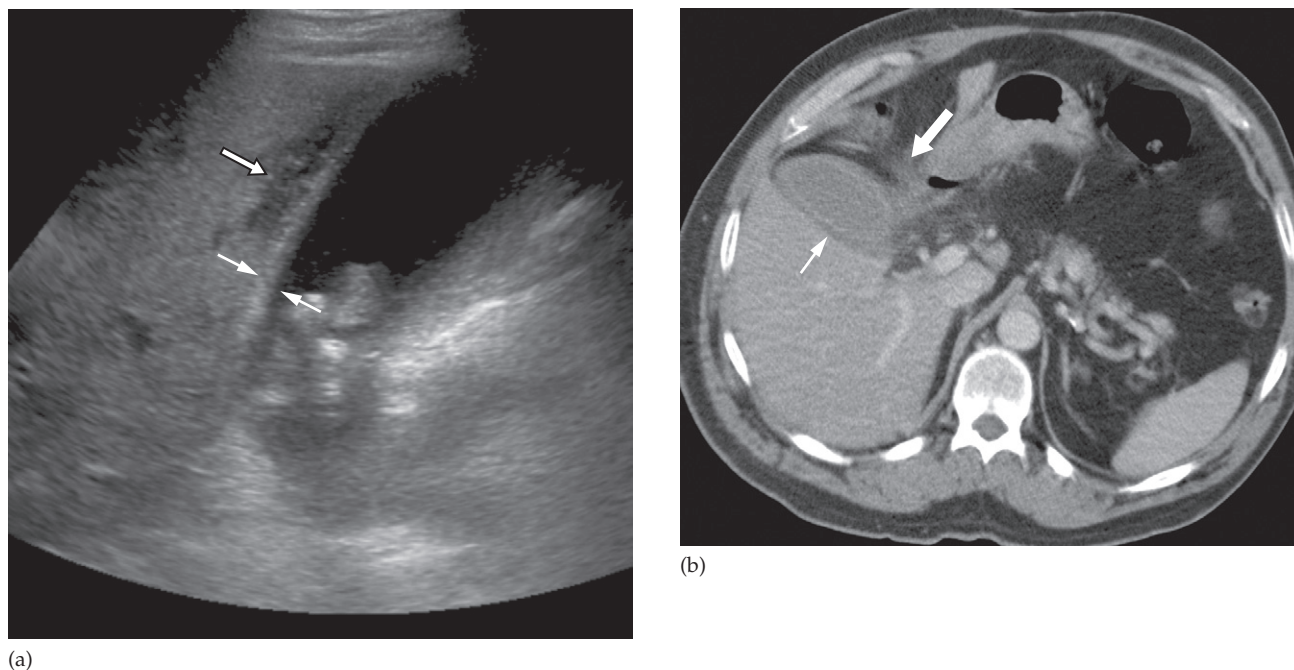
Acute cholecystitis. (a) Ultrasound showing a thick, oedematous gall bladder wall indicated by the thin arrows. There is also evidence of fluid adjacent to the gall bladder indicative of acute inflammation (thick arrow). (b) CT scan of acute cholecystitis showing a thick-walled gall bladder with adjacent oedema and inflammatory change as evidenced by a surrounding low attenuation rim (thin arrow) and lack of clarity (stranding) in the adjacent fat (thick arrow).
